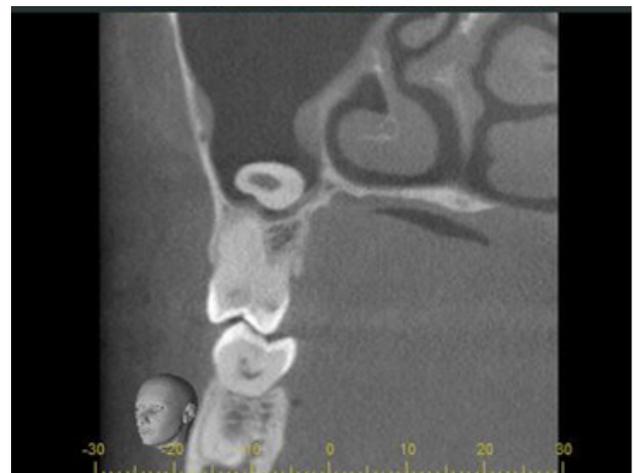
A heterotopic right maxillary third molar tooth in the maxillary sinus on coronal CBCT sections and white arrow shows the heterotopic teeth.
